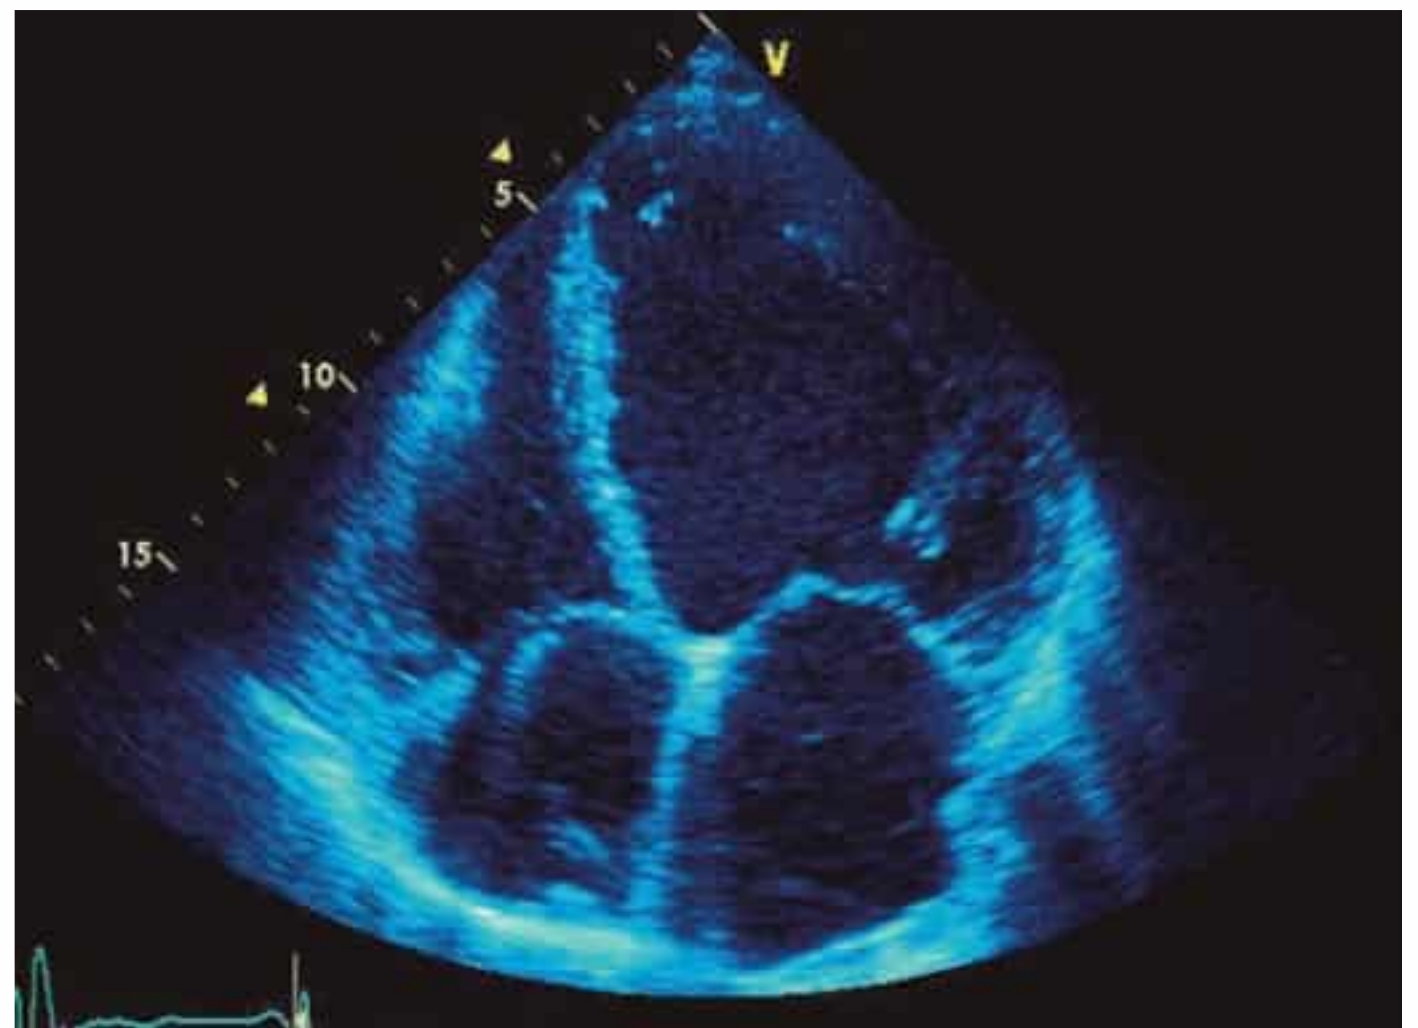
Echocardiography. End-diastolic four-chamber view of a spherically dilated left ventricle in DCM.
